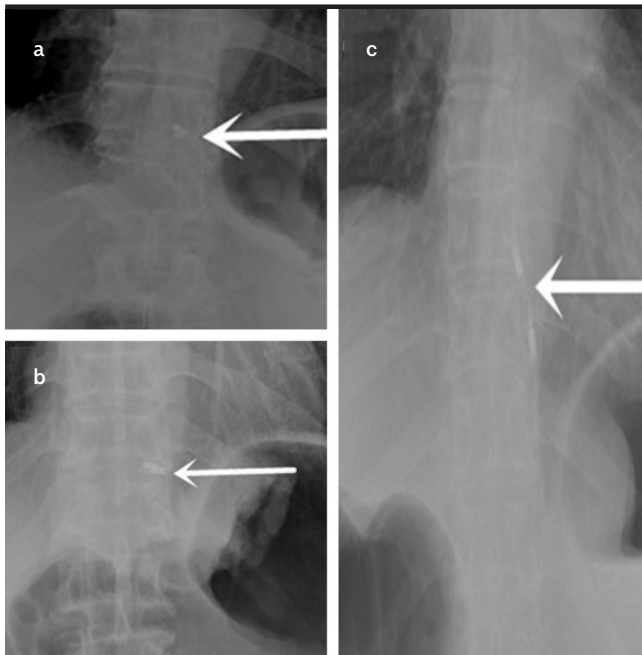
a-c. Abdominal plain film showing a peptide clip (arrow).
